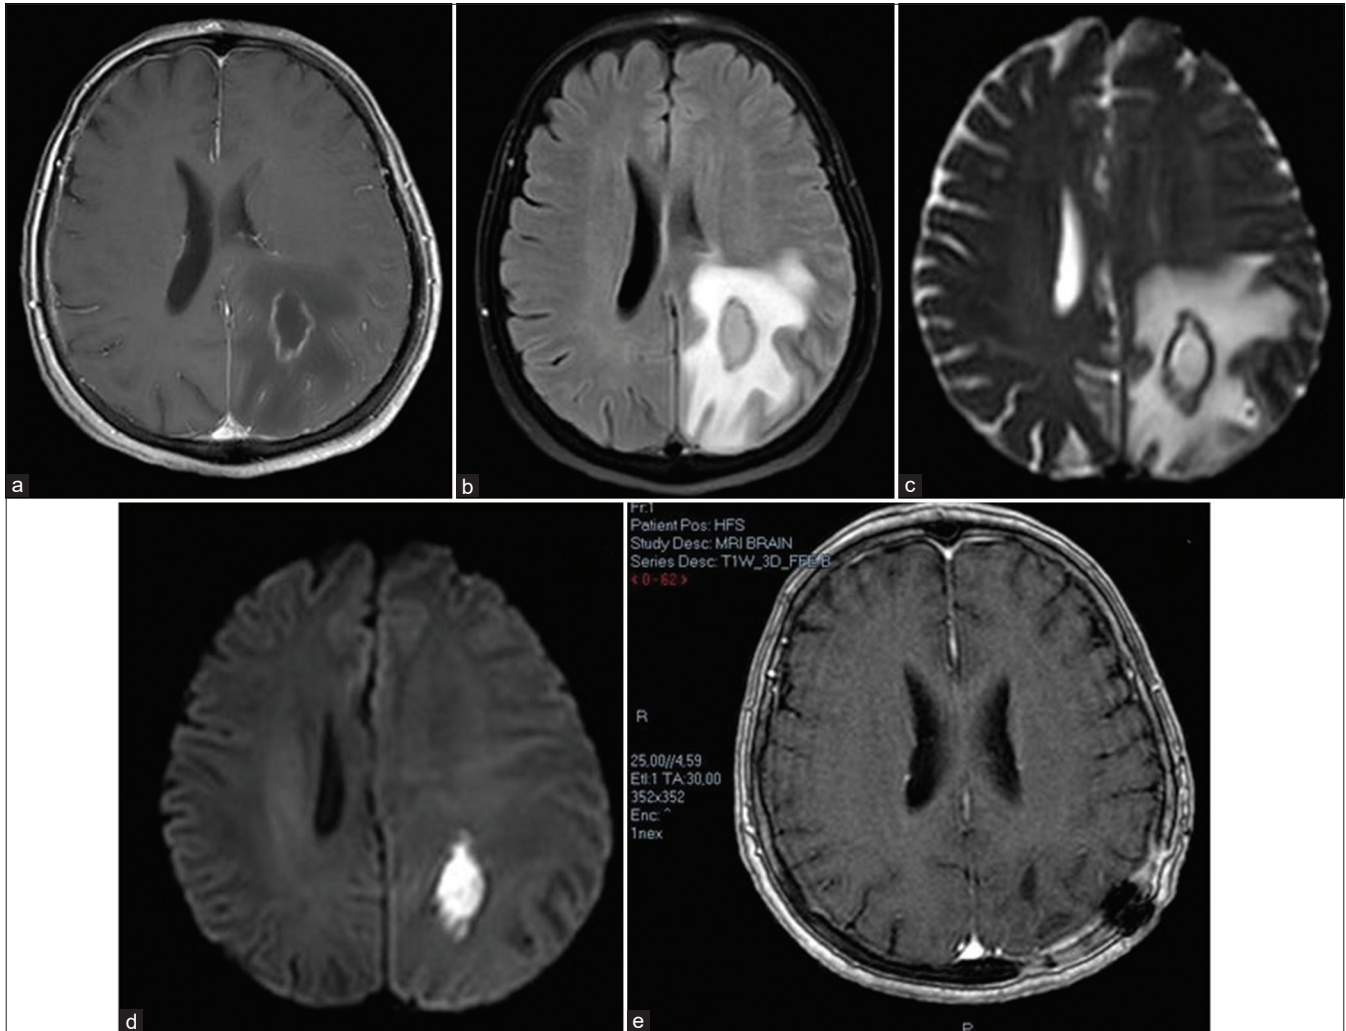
Axial brain MRI images demonstrate a rim-enhancing (a), collection of fluid which does not attenuate on FLAIR (b), with true diffusion restriction (c and d), indicative of a brain abscess. Postoperative image (e) was acquired 2 months after evacuation and demonstrates no signs of fluid collection or gadolinium enhancement.
